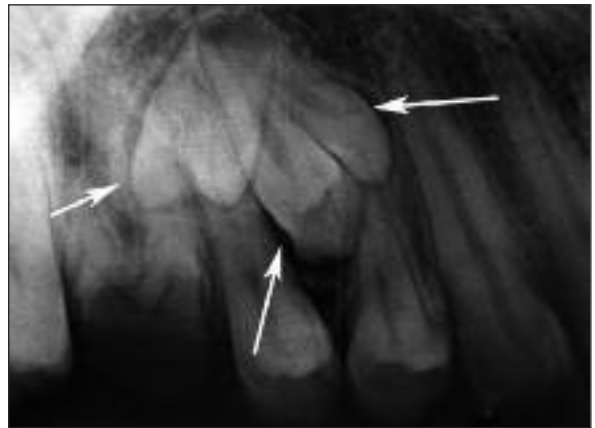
Periapical radiography of the right maxillary premolar region showing three supernumerary premolars (arrows).
